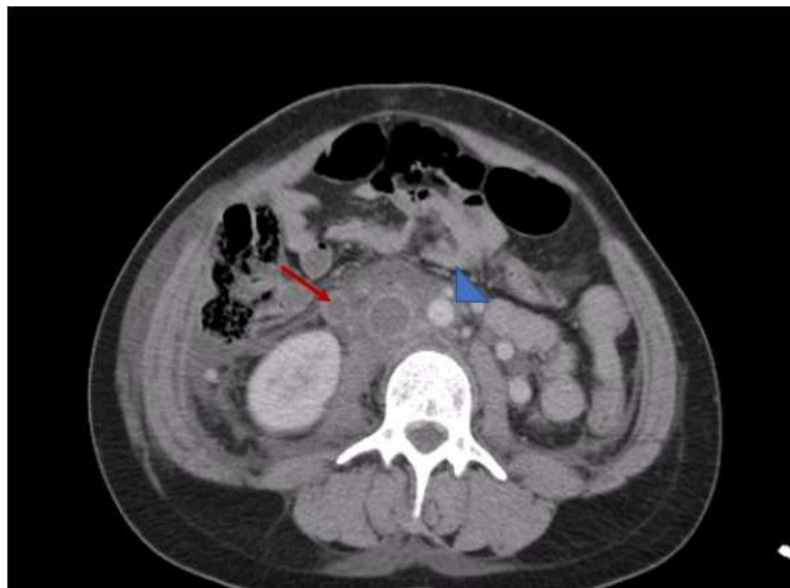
Abdominal CT scan (axial view, contrast-enhanced) showing a right ovarian vein thrombosis with an endoluminal thrombus appearing as a hypodense filling defect (red arrow) and the left ovarian vein (blue arrow). Radiology Department, Mother-Child Unit, CHU Hassan II, Fes.
